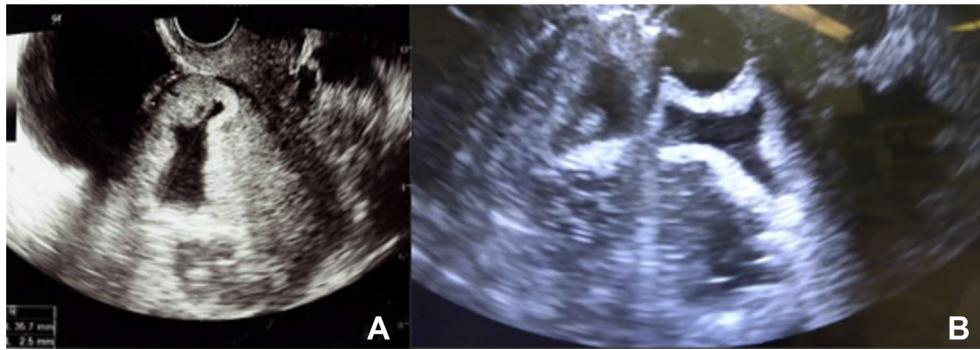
(A) Transvaginal ultrasonography on admission showing the thin anterior uterine myometrium (2.5 mm) and the gestational sac attached to the cesarean scar. (B) Sonohysterography showing the gestational sac floating in the water.
